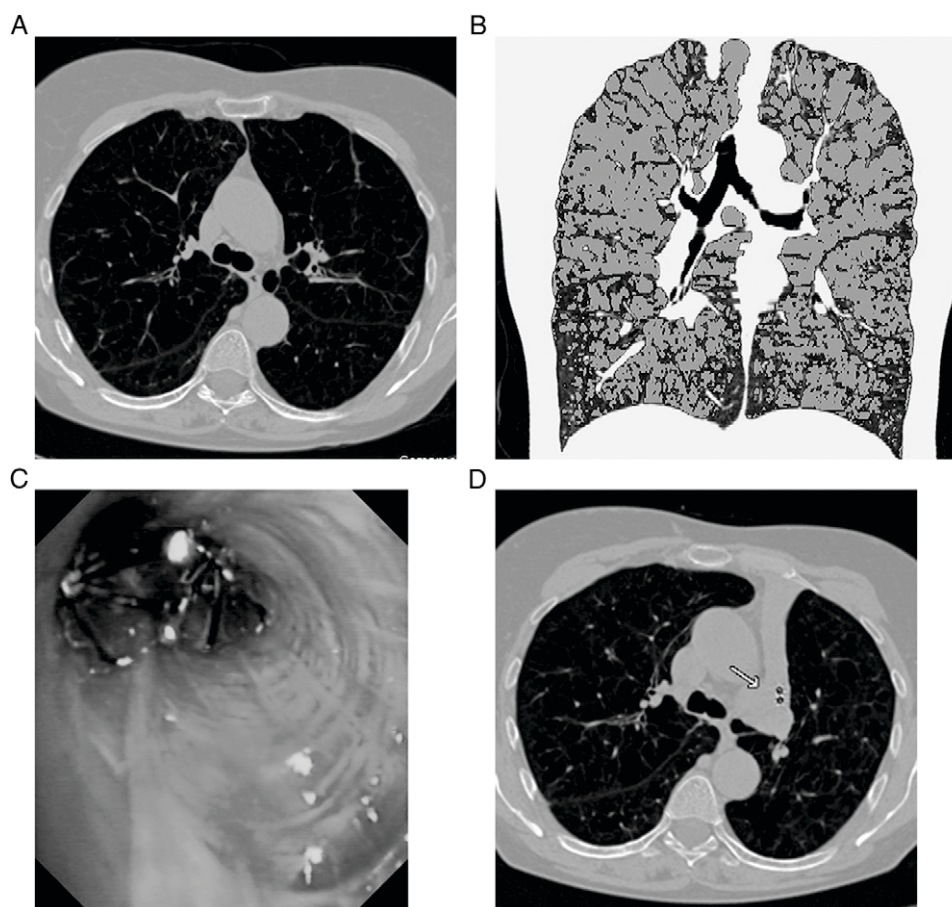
Patient No. 7 treated in the unilateral arm with complete closure of the left upper lobe. A, CT scan prior to valve placement. B, Corresponding software analysis shows bilateral upper-lobe-predominant emphysema. C, Endoscopic image with two intrabronchial valves occluding the left upper lobe. D, Corresponding CT scan after 90 d with complete atelectasis of the treated lobe. Arrow indicates two implanted intrabronchial valves.
